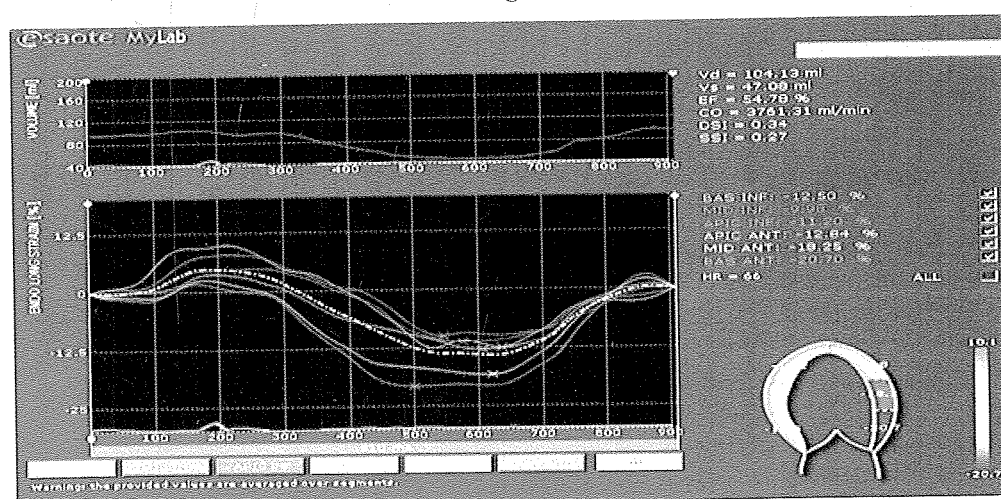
Strain echocardiography in a patient with significant left anterior descending coronary artery stenosis and right coronary artery stenosis shows a marked heterogeneous pattern of peak systolic strain in the apical 4-chamber view ( Fig 2 ) and the apical 2-chamber view ( Fig 3 ).
